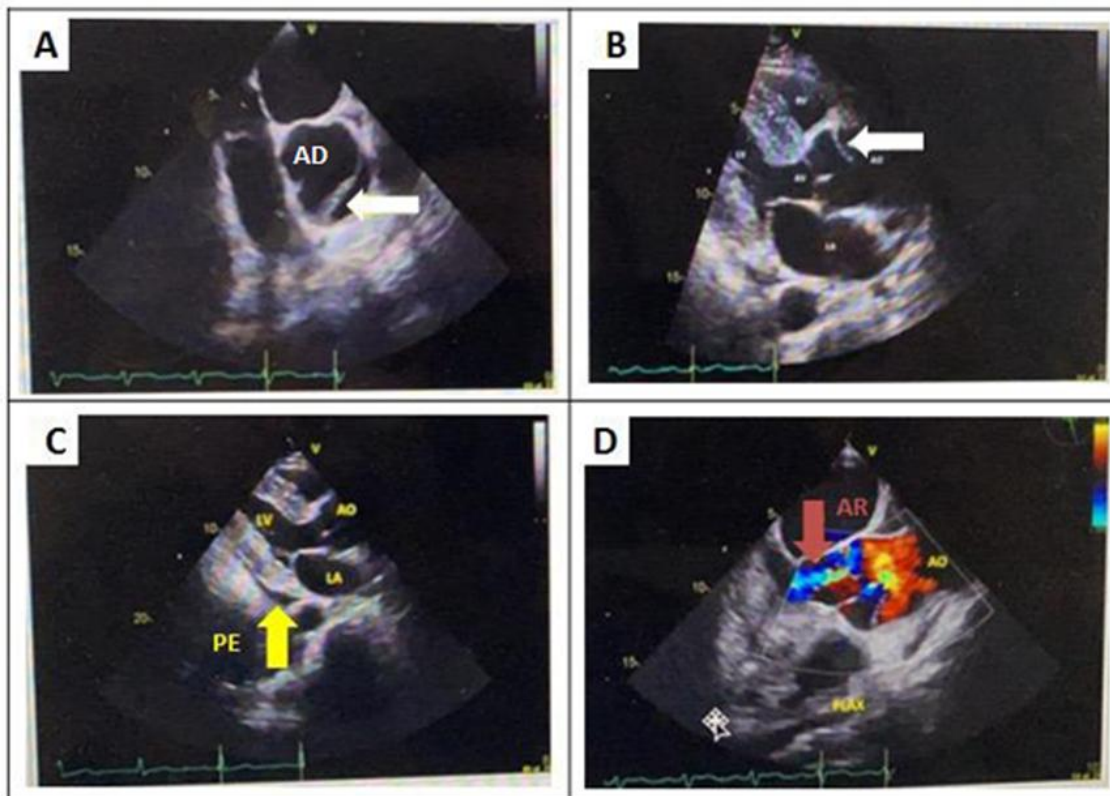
A-D echocardiographic views revealed a suspicion of a flap at the aortic root (white arrow), mild pericardial effusion (yellow arrow), and echocardiographic aortic regurgitation (red arrow).
